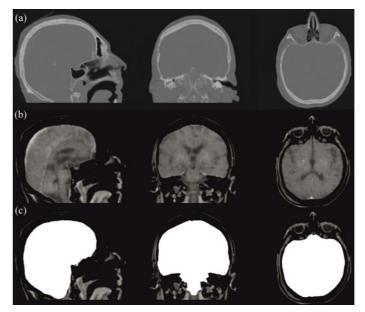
Example of image processing to calculate the intracranial volume for the computation of the NCW. Left: sagittal plane, middle: coronal plane, right: axial plane. (a) Original CT images. (b) Thresholded and smoothed images. (c) Segmentation of the intracranial volume (picture: M. Bauer).
